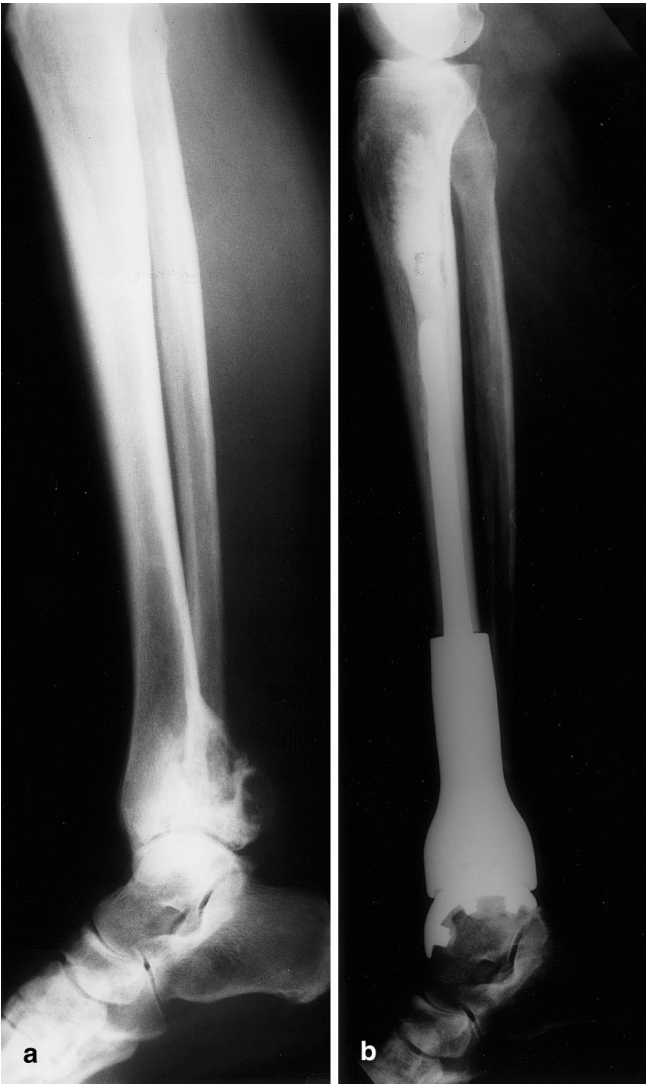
Plain radiographs of Chondromyxoid fibroma of the distal tibia (a) treated by excision and endoprosthetic reconstruction (b) after two failed curettage procedures
